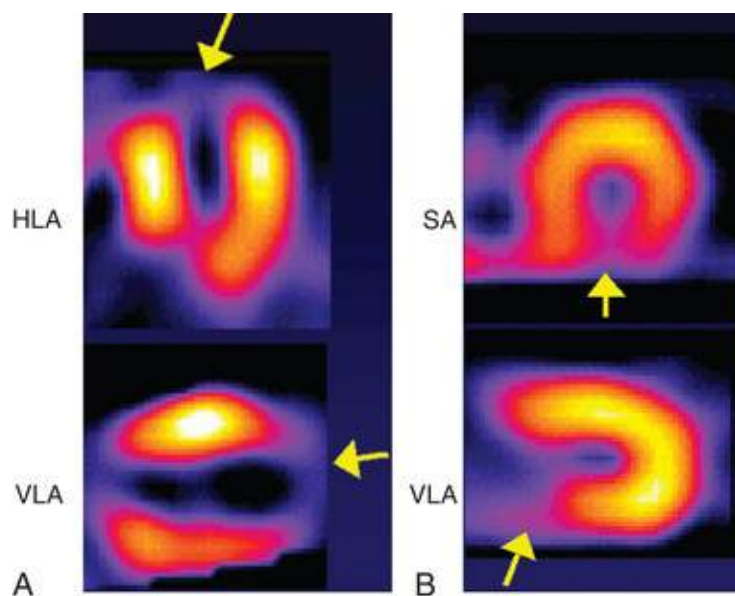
SPECT perfusion images demonstrating myocardial infarction in different locations. A, An apical infarction (*arrows*) in the horizontal long-axis (HLA) and vertical long-axis (VLA) views. B, An inferior infarction (*arrows*) in the short-axis (SA) and VLA views. In both studies, the severity of the defect suggests minimal myocyte viability within those territories.
